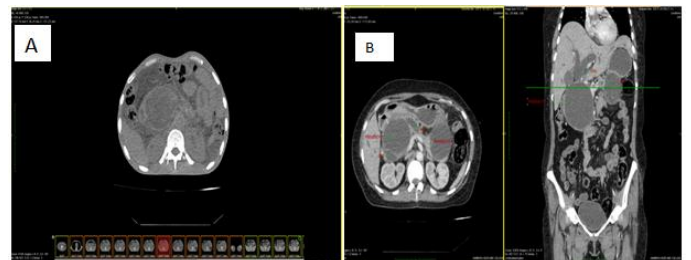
CT unenhanced axial (A) shows a pseudo-pancreatic cyst in pancreatic head region and (B) axial and coronal enhanced parenchymal phase shows a pseudo-pancreatic cyst in pancreatic head and tail region with cyst in head region causing compression over second part of duodenum resulting in dilatation of both CBD and MPD giving double duct sign.
